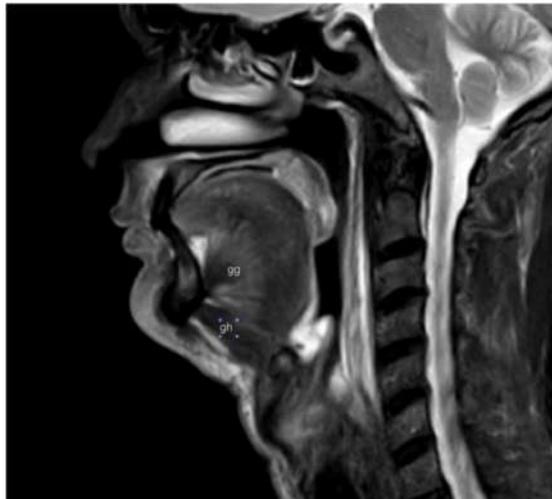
Anatomy: Sagittal T2-weighted MR image demonstrates dark-hypointense geniohyoid muscles (gh) from genial tubercle to hyoid and the fan-shaped genioglossus muscles (gg).
